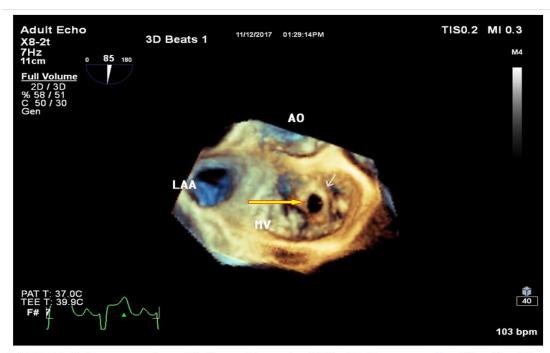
Transoesophageal Echocardiography With 3D Reconstruction Showing The Anterior Mitral Leaflet Aneurysm (white arrow) From Ventricular Side With Perforation (yellow arrow). MV: mitral valve, AO: aorta, LAA: left atrial appendage.
